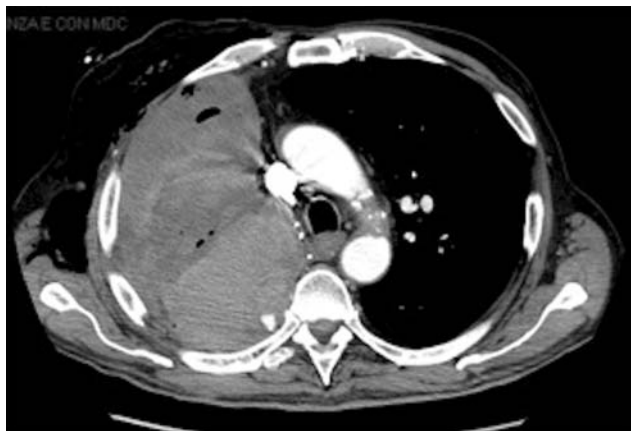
Chest CT performed for weakness, dyspnea and hemoglobin loss, shows the hemothorax due to the intercostal artery leakage. At discharge the thorax X-ray and the lab test did not show any acute bleeding sign.
